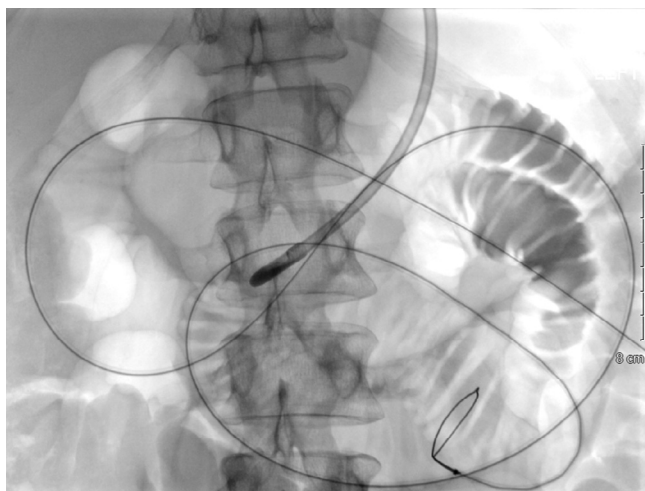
From the percutaneous gastric access, a loop snare is advanced over a guidewire into the mid-jejunum. Ultrasound (not shown) confirmed that the loop of bowel containing the snare was superficial, without intervening bowel loops.
